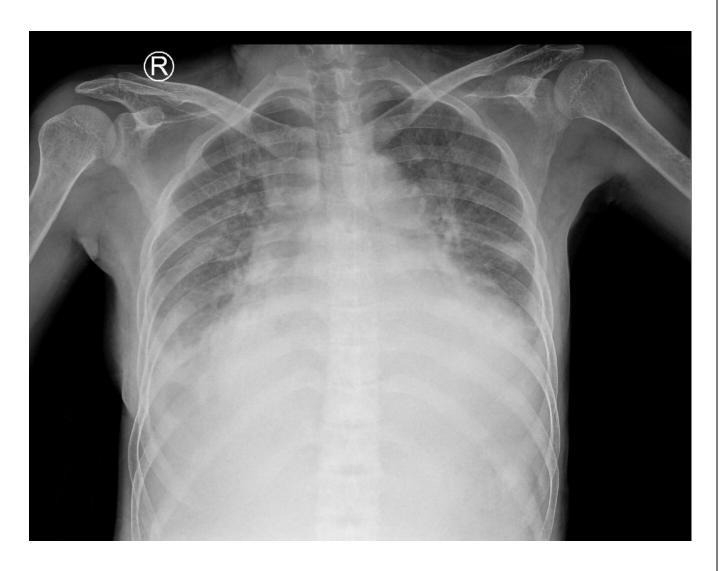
Chest X-ray of the patient showed bilateral pneumonia.
